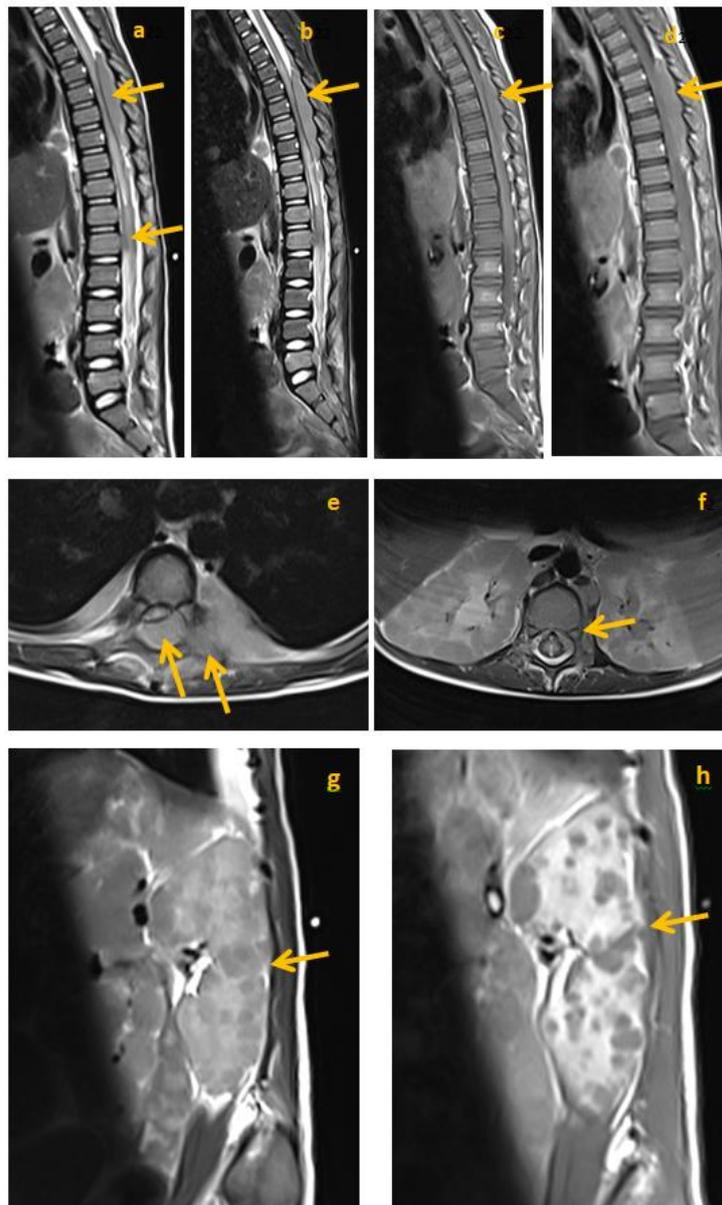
MRI of the thoracic and lumbar spine.
